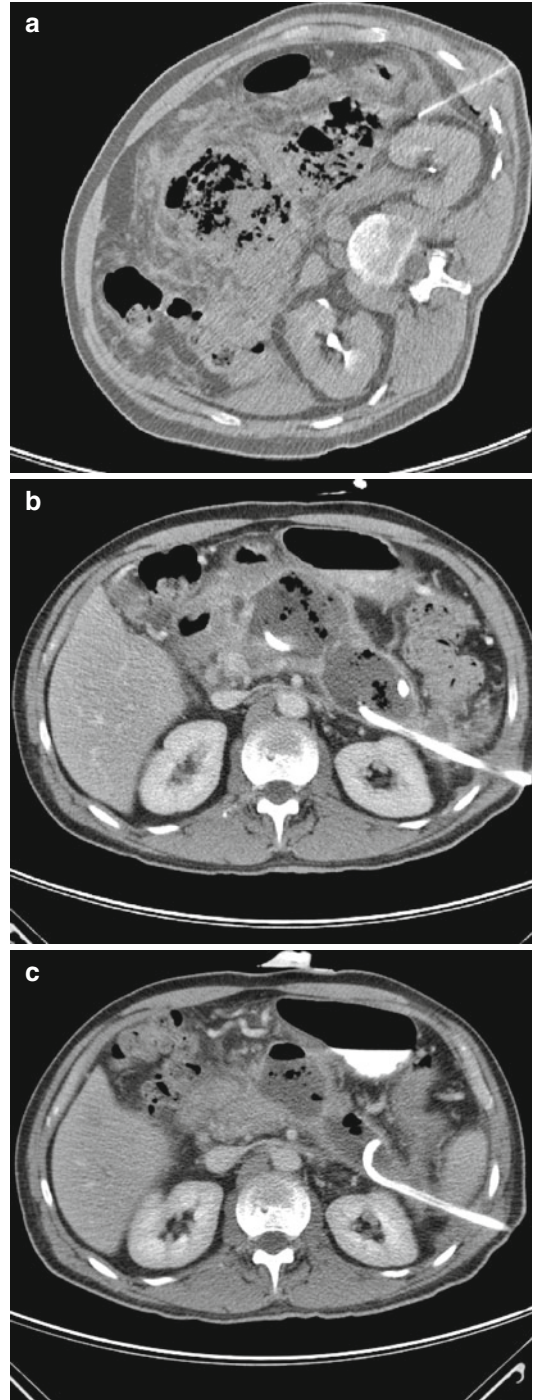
Left lateral access to the pancreas in severe necrotizing pancreatitis. The puncture was performed with CT fluoroscopy guidance to access the pancreatic tail region, avoiding bowel injury by passing close to Gerota's fascia (a). A second drainage catheter was placed from a ventral access. The follow-up scan after 4 days with continuous irrigation and significant clinical improvement depicts the two catheters in place (b). The pancreatic bed is fluid-filled and contains air bubbles as well as necrotic tissue. Follow-up CT after 2 weeks with both catheters still in place shows a further decrease of the abscess cavity (c)
